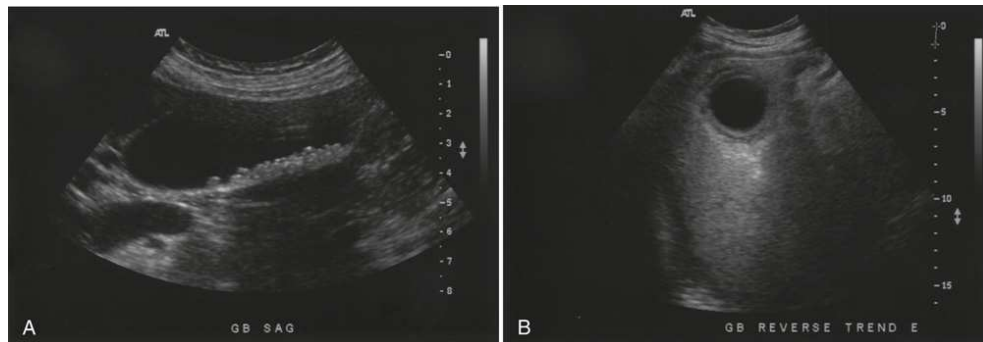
(A) Sagittal sonogram of gallbladder showing multiple small gallstones with posterior acoustic shadowing. (B) Transverse sonogram of acute cholecystitis.
